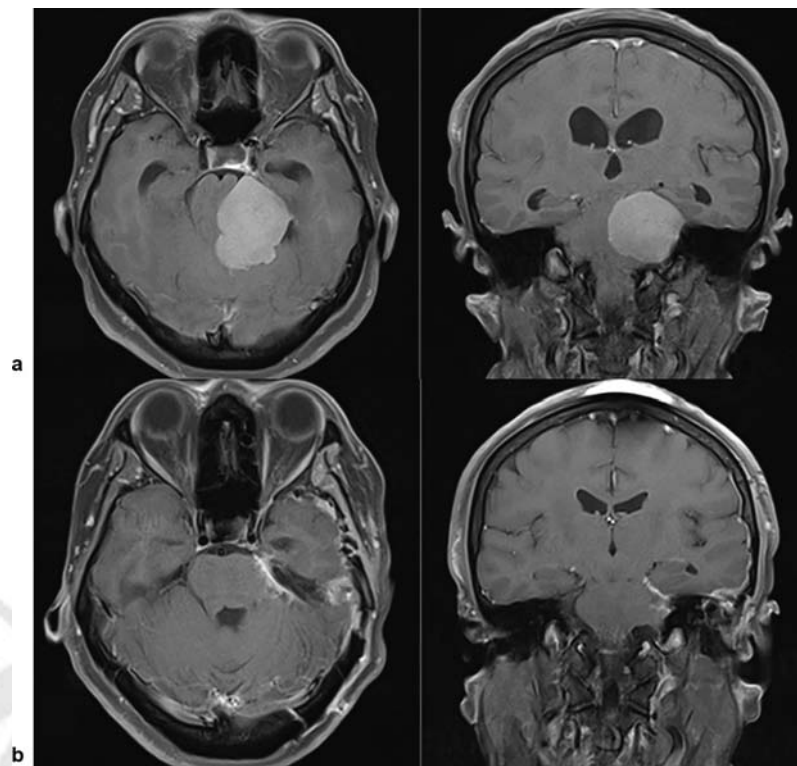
Preoperative magnetic resonance imaging (MRI) showed homogenous contrast-enhanced mass at the left petroclival region. Two-month postoperative MRI: Tumor infiltration of brainstem arachnoid made total resection without high risk of brainstem infarction impossible.
